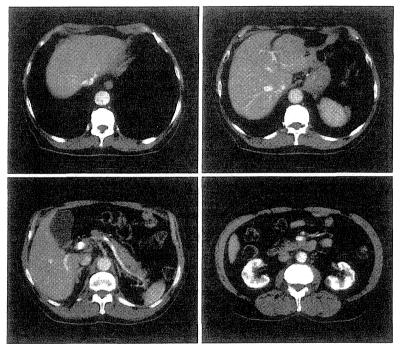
化学療法後腹部 CT 残胃の壁肥厚はほぼ消失。多発の肝転移もほぼ消失、さらに大動脈周囲 を含めたリンパ節腫脹も消失した。
